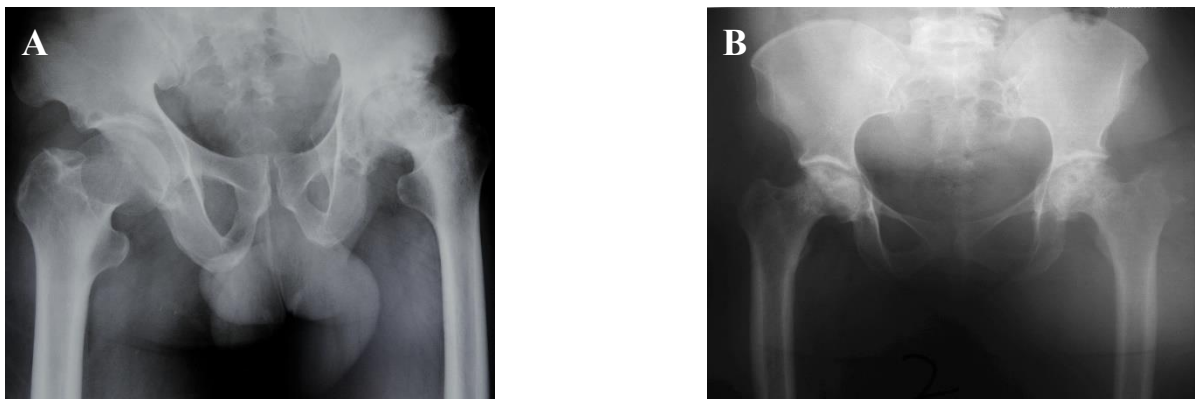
Radiographs showing hip pathology characteristic of Mseleni Joint Disease (MJD). (A) Bilateral hip dysplasia, with subchondral cysts and femoral head flattening (more severe on the right) in a man with MJD. (B) Bilateral hip arthrosis with protrusio acetabuli and femoral head cyst, ovoid deformity leading to severe restriction of abduction, adduction and rotation in a woman with MJD. [Radiographs sourced from medical records at the Mseleni Hospital (HREC: 079/2019). Pathology described by V Fredlund, personal communication 2019, August 8th].
